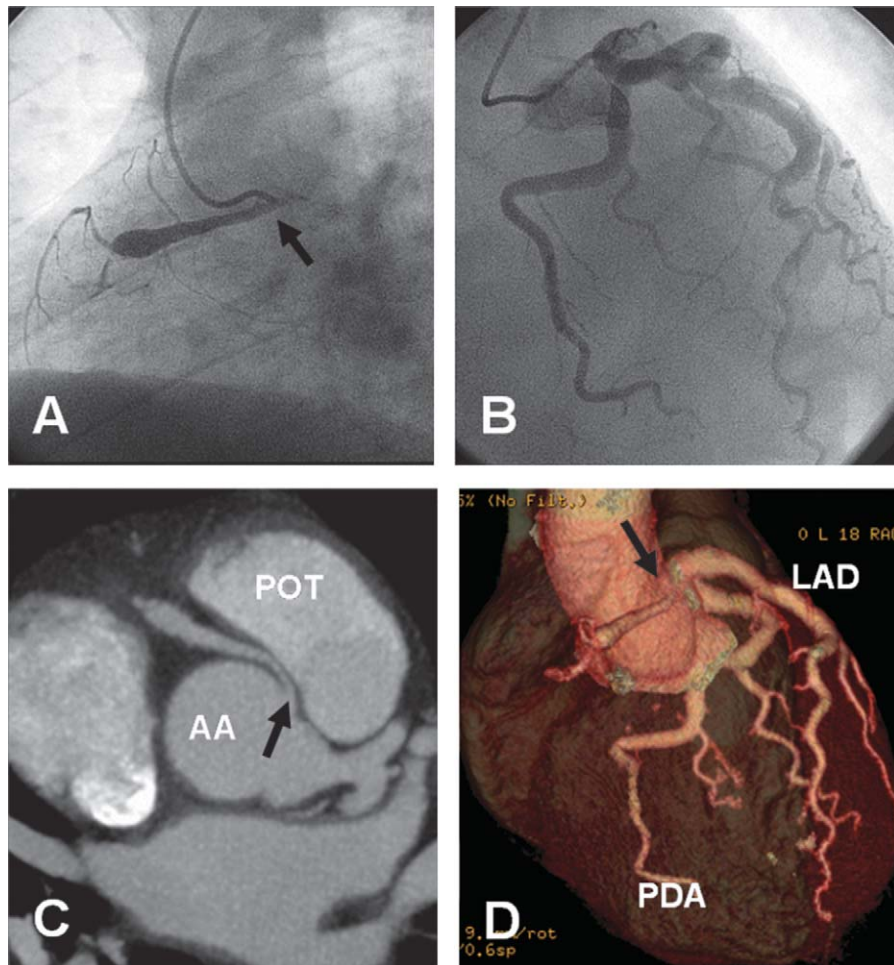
Upper panel shows left anterior oblique view of the RCA (A) and right anterior oblique view of the left coronary system (B) on coronary angiography. A demonstrates the proximally occluded RCA, and B shows the large ectatic left coronary artery. Note, the large left coronary system including a dominant left circumflex artery giving rise to the posterior descending artery (PDA). Lower panel shows axial MDCT image at the level of the RCA origin (C) and a 3-dimensional volume-rendered reconstruction of the coronary vessels corresponding to the same projection obtained by coronary catheterization (D). Anomalous origin of the RCA above the anterior commissure of the ascending aorta is shown. The proximal RCA appears funnel-shaped and compressed between ascending aorta (AA) and right ventricle outflow tract (RVOT) with a short intramural segment at the origin (black arrows). It is occluded approximately 25 mm from its orifice. LAD indicates left anterior descending artery; MDCT, multidetector computed tomography; RCA, right coronary artery.
